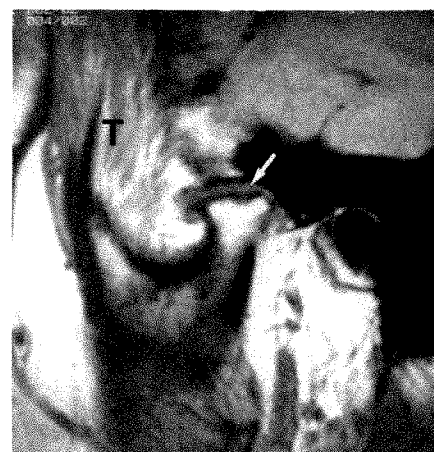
Temporalis atrophy and fatty replacement associated with long-standing rheumatoid arthritis and painful, degenerated TMJ. Sagittal, closed-mouth MR image, 600/20, reveals increased fat within temporalis (T) muscle. Note absence of meniscus from fluid-filled joint compartment (*arrow*) and flattening of mandibular condyle. Meniscus (not seen) was dislocated anteromedially on more medial images.
